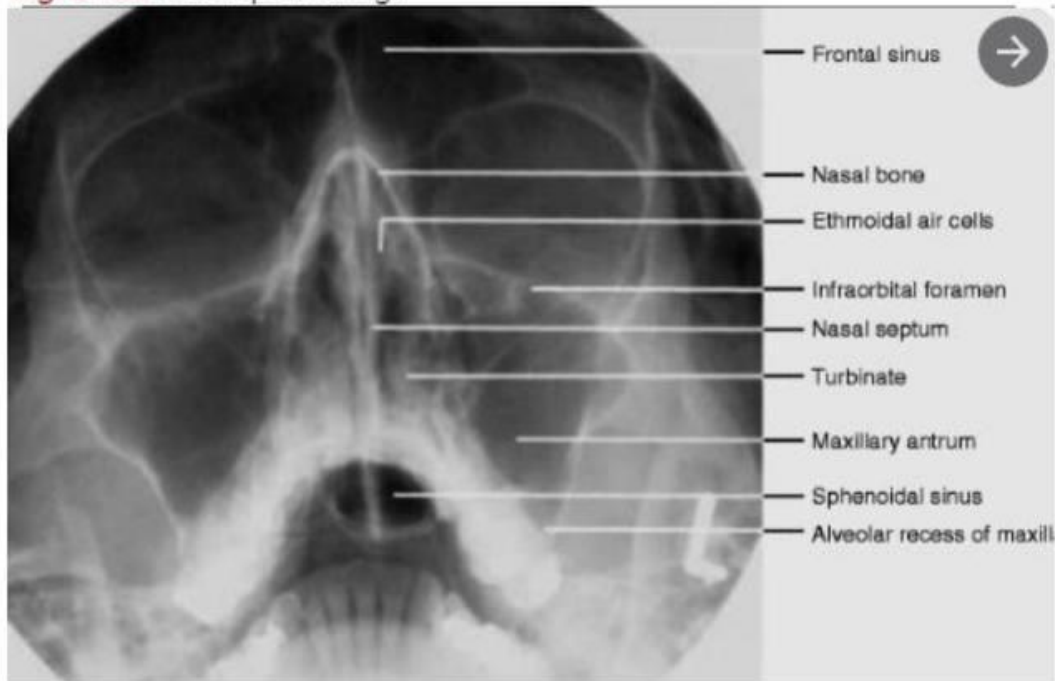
OM radiograph with the mouth open.
